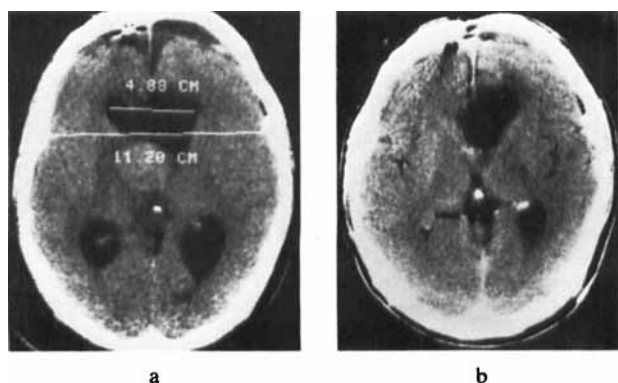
Same case as in Fig. 1. a) Post-operative CT before irradiation shows residue of tumour. b) Follow-up two months later shows complete response of the tumour.
